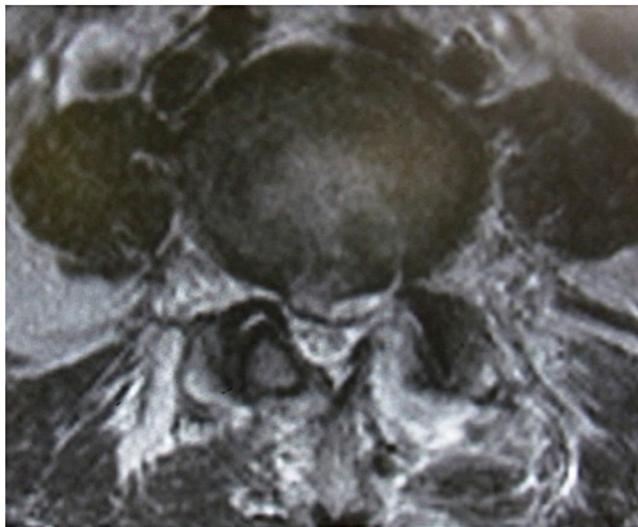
After first operation, MRI showed a disk herniation at L4/5 on the right side of the spinal canal.
